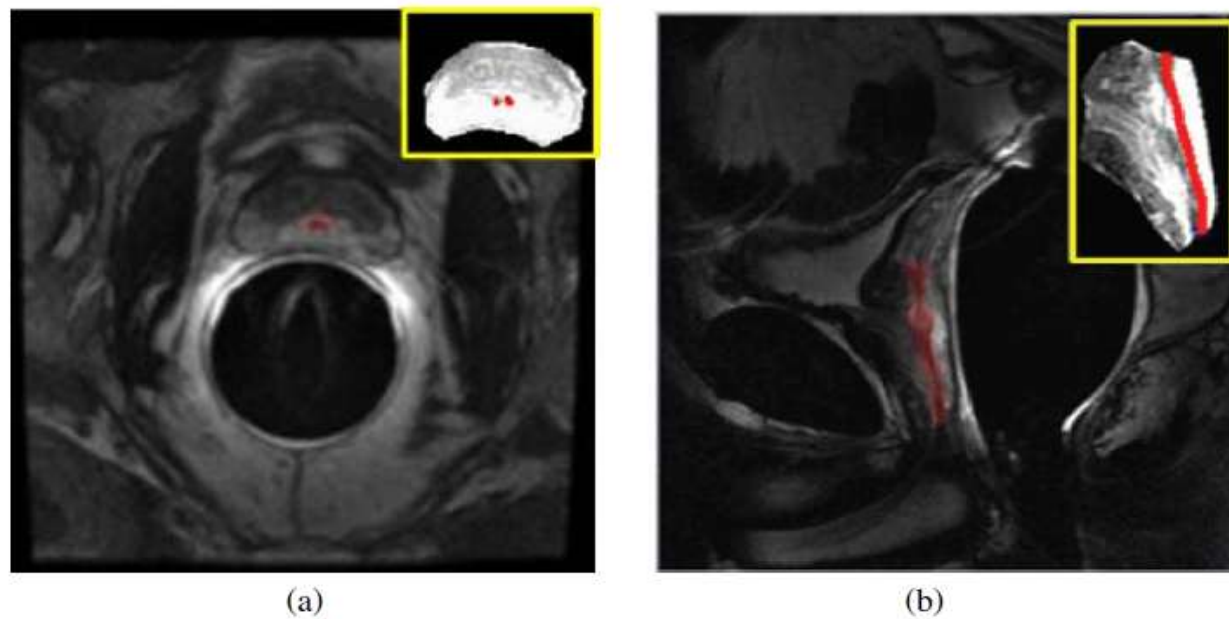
Results of our automatic feature detection design for (a) the axis and (b) the sagittal MR images. The small images highlighted by yellow frames show detected features (red points or line) in the prostate region.
